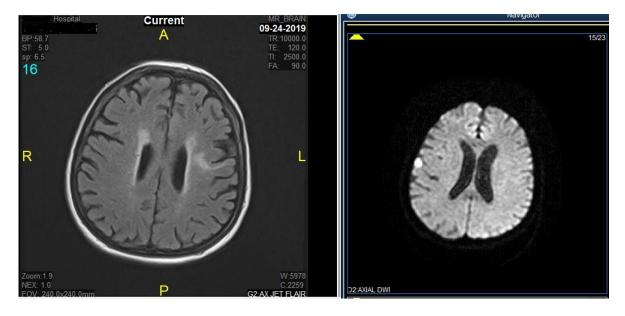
MRI demonstrating subacute infarct in the left frontal lobe at the gray white matter junction
